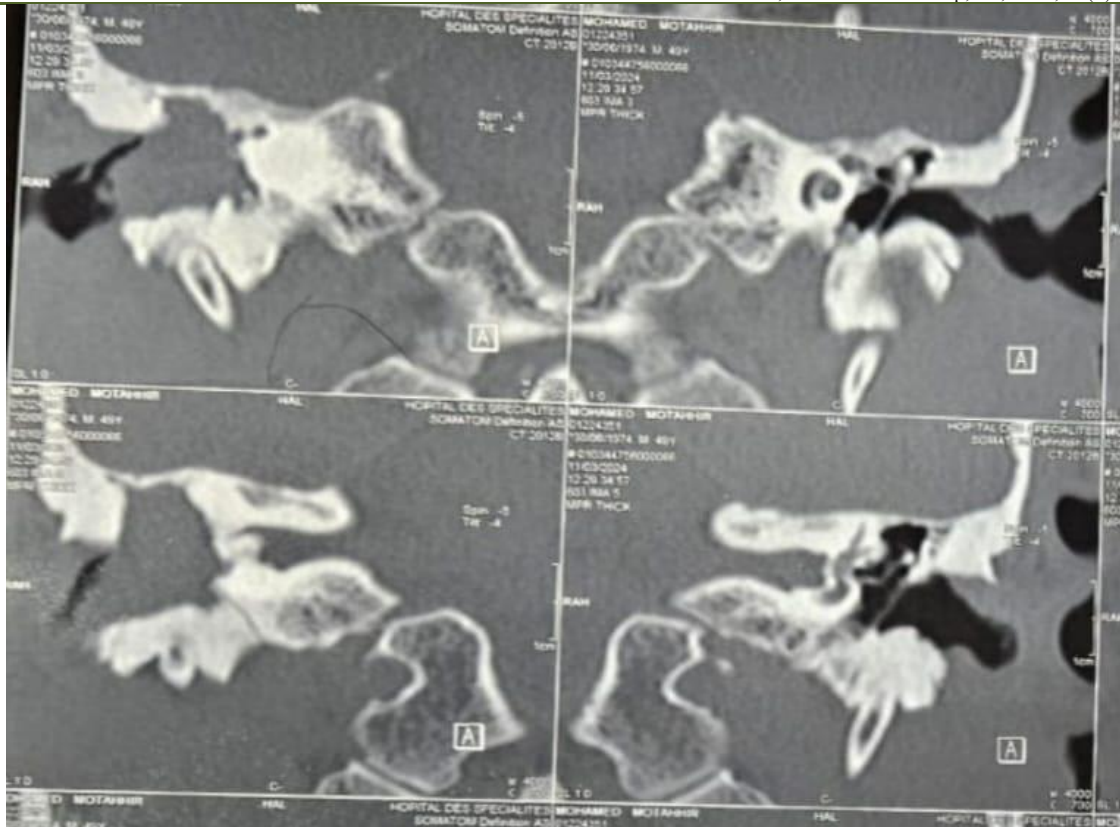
Coronal CT scan of the temporal bone showing a soft tissue density filling the right middle ear and mastoid cavity, consistent with cholesteatoma. Ossicular chain erosion and facial canal involvement are also noted
